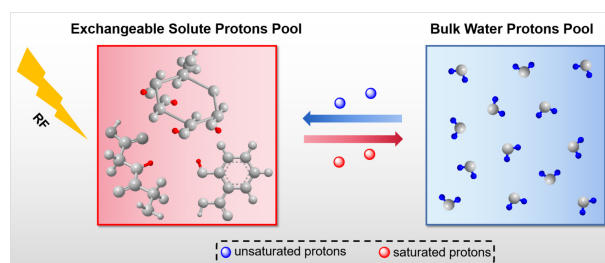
The underlying principle of CEST MRI via a two-pool model.
